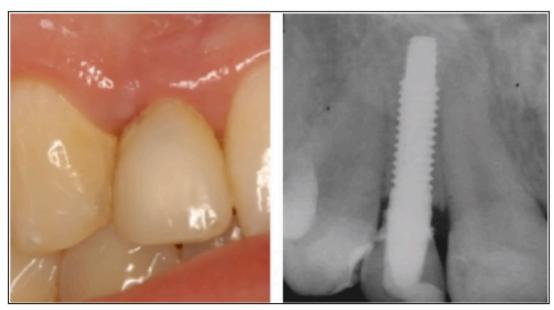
Peri-implant mucositis clinical and radiographic presentation.
